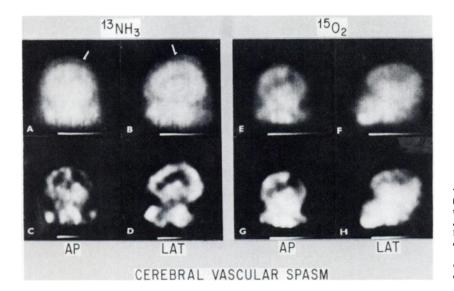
Positron scintigrams in 40-year-old man with cerebral vascular spasm. (A,B) ¹⁸NH₃ scintigrams obtained after intravenous administration; (C,D) scintigrams A and B with brightness gradients enhanced; (E,F) ¹⁸O₂ scintigrams obtained at equilibration with ¹⁸O physical decay during inhalation of ¹⁵O₂ in air; (G,H) scintigrams E and F with brightness gradients enhanced.
